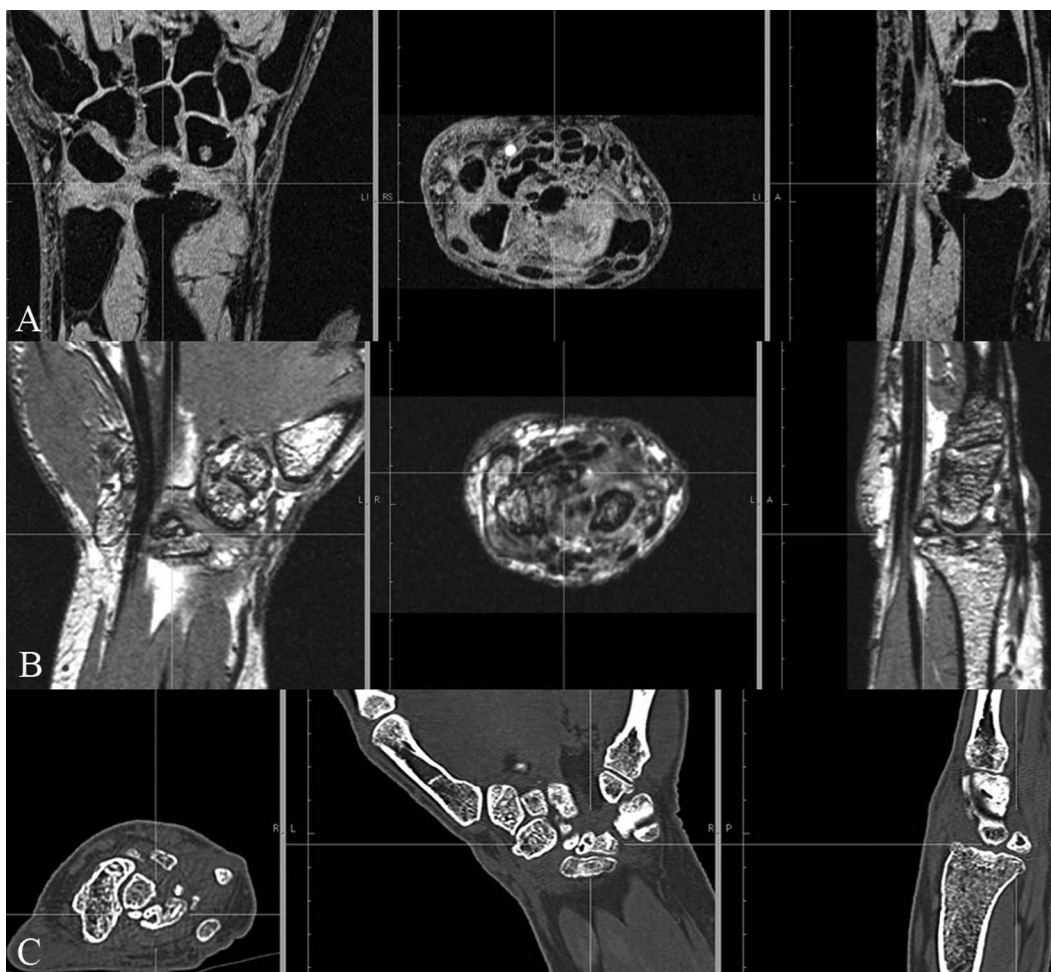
Ossification in the palmar side of the defect filled by the tendon ball. High resolution (A) coronal MRI 3D VIBE and (B) coronal MRI 3D DESS reconstructed on the axial and sagittal planes. (C) CT axial acquisition with coronal and sagittal reconstruction.
